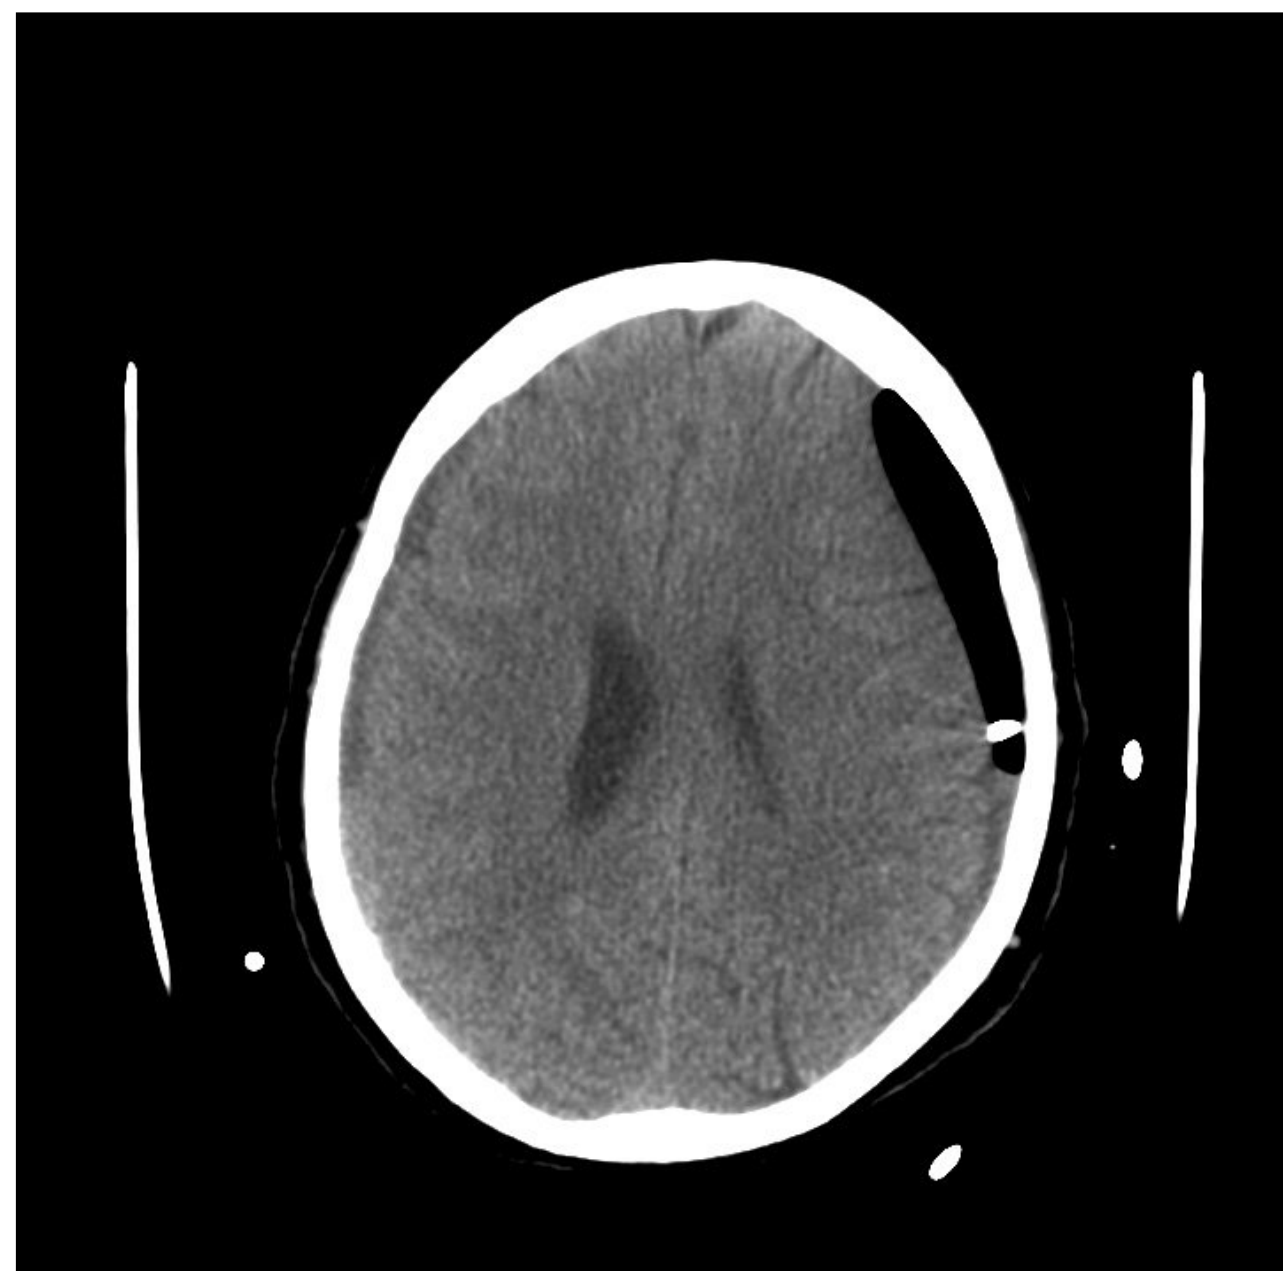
Postoperative CT scan of the patient in Fig. 2.1 undergoing bur hole drainage with drain in place. There is pneumocephalus and improvement in mass effect. The patient also has a smaller subacute right parietal subdural collection which was treated conservatively.
